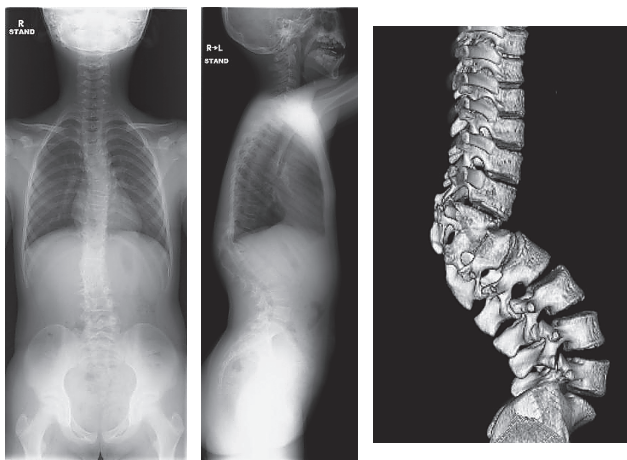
Preoperative radiographs and 3-D CT.
